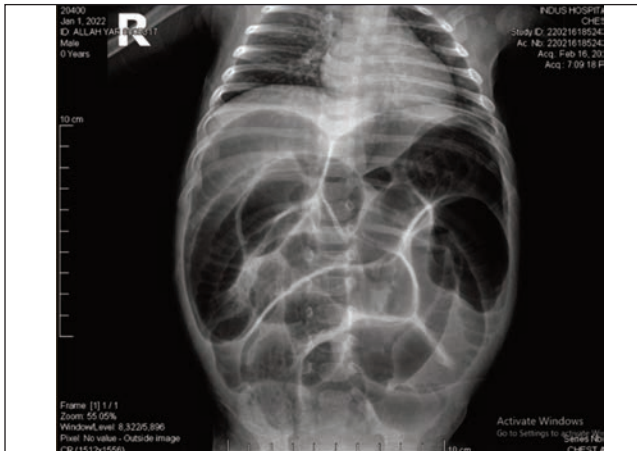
Plain radiograph with dilated bowel loop.
